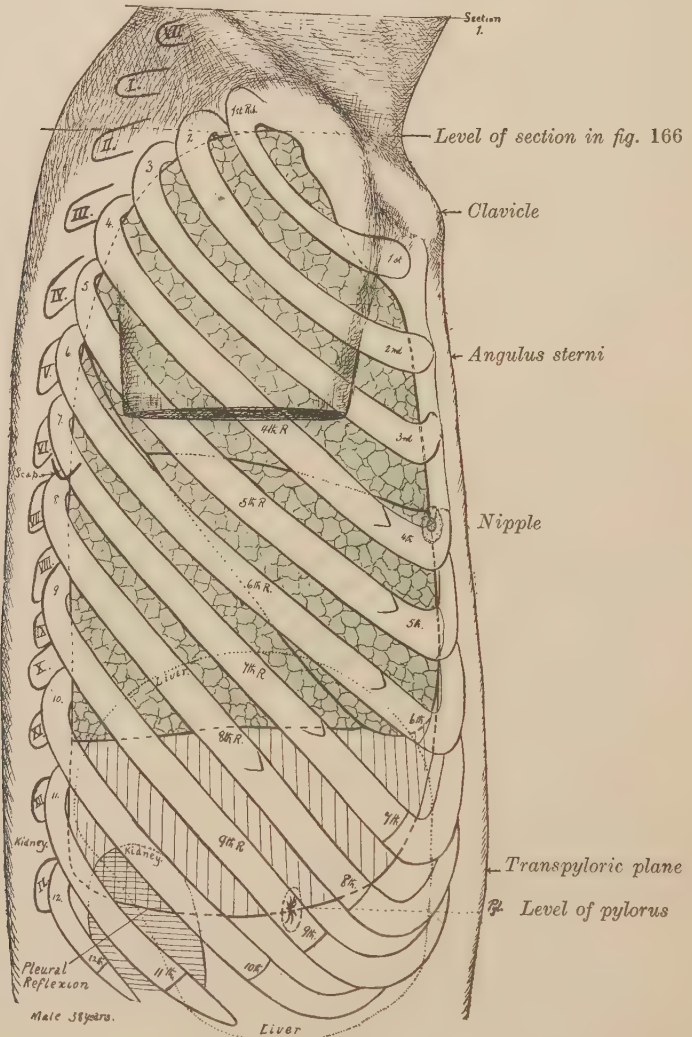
RIGHT LATERAL ASPECT OF THE THORAX OF A MAN AGED THIRTY-EIGHT YEARS, SHOWING THE POSITION OF THE LUNG (BLUE). One-third natural size. (J. S. Dickey.)
